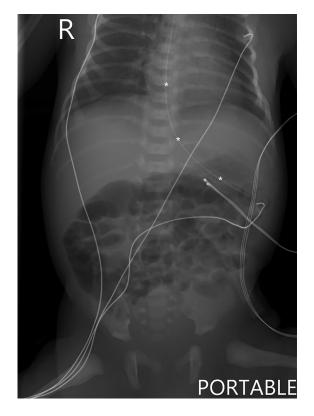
Frontal radiograph of the chest and abdomen on Day 1 of life. Note normal findings and the prophylaxis nasogastric tube (marked with white asterisks) placed for decompression.
